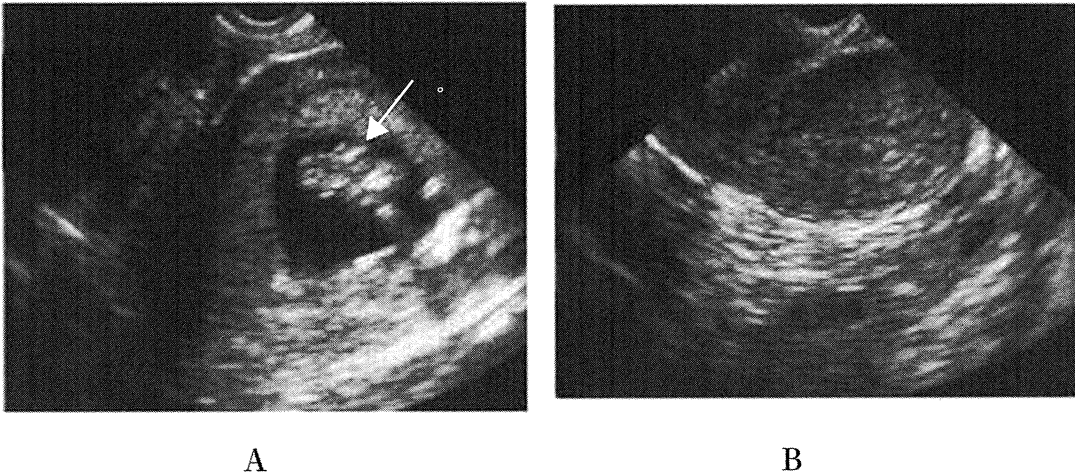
(A), Trans vaginal ultrasonic echo when the potassium chloride was injected to the heart of the fetus with a 23 gauge liver biopsy needle assisted by trans vaginal ultrasonic echo at 9 weeks of pregnancy. White arrow: needle, (B), trans vaginal ultrasonic echo at postoperative day 9. Complete abortion was confirmed.
